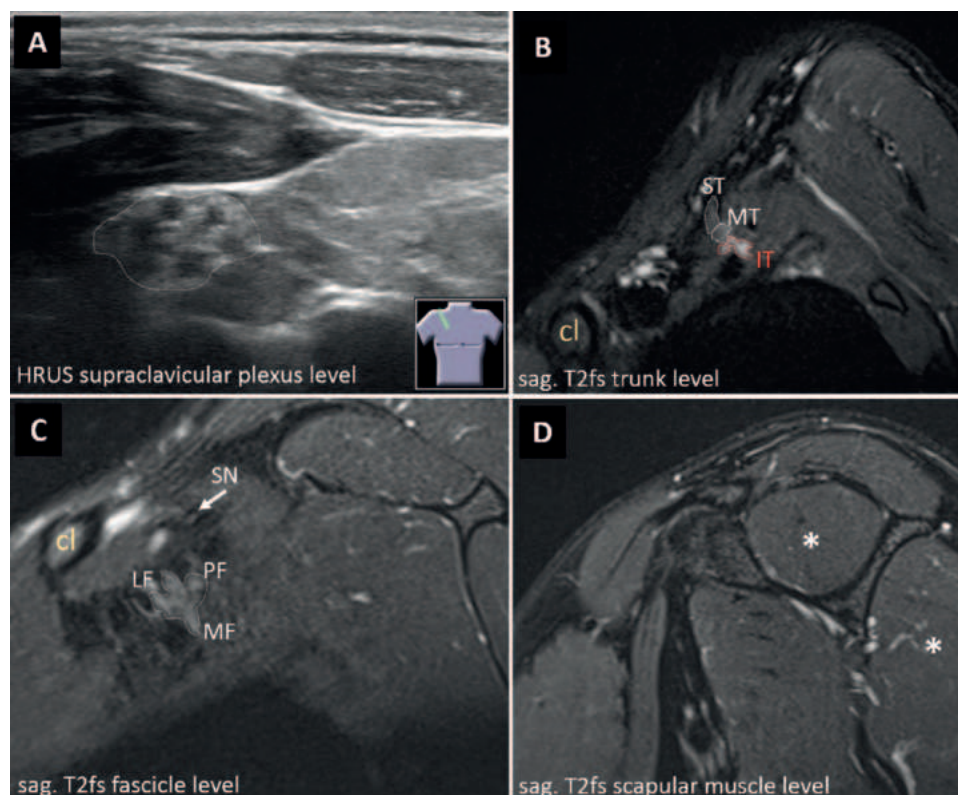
High-resolution nerve US (HRUS) images (A, C) show superior specificity to MR neurography (MRN) images (B, D). A 24-year-old male participant presenting with recurrent and exacerbating pain in his right shoulder with a difficulty to elevate (Medical Research Council grade 4+) his arm following a sports-related injury 1 year prior to imaging to rule out suspected plexus neuritis. At electrophysiologic examination, only a borderline spontaneous activity pattern of the infraspinatus muscle was reported. (A) HRUS image shows the supraclavicular plexus (dotted white line), which was normal without alterations in nerve echogenicity or diameter suspicious for peripheral neuropathy. (B) MRN images in the proximal brachial plexus show a T2-weighted signal increase at the conjunction of the inferior trunk (IT, red dotted line) next to the unremarkable superior trunk (ST) and middle trunk (MT). However, there were no related clinical or electrophysiologic findings. (C) Sagittal (sag.) T2-weighted fat-saturated (T2fs) HRUS image shows normal distal, infraclavicular plexus segments with the lateral fascicle (LF), medial fascicle (MF), posterior fascicle (PF), and suprascapular nerve (SN). (D) MRN image shows no signs of muscular denervation of the supraspinatus or infraspinatus muscles (*). Therefore, a plexus neuritis or another nerve-related etiologic cause was ruled out. An artificial signal increase, often caused by the so-called magic angle artifact, can lead to false-positive findings at MRN and must be considered when interpreting findings at MRN. cl = clavicle.
